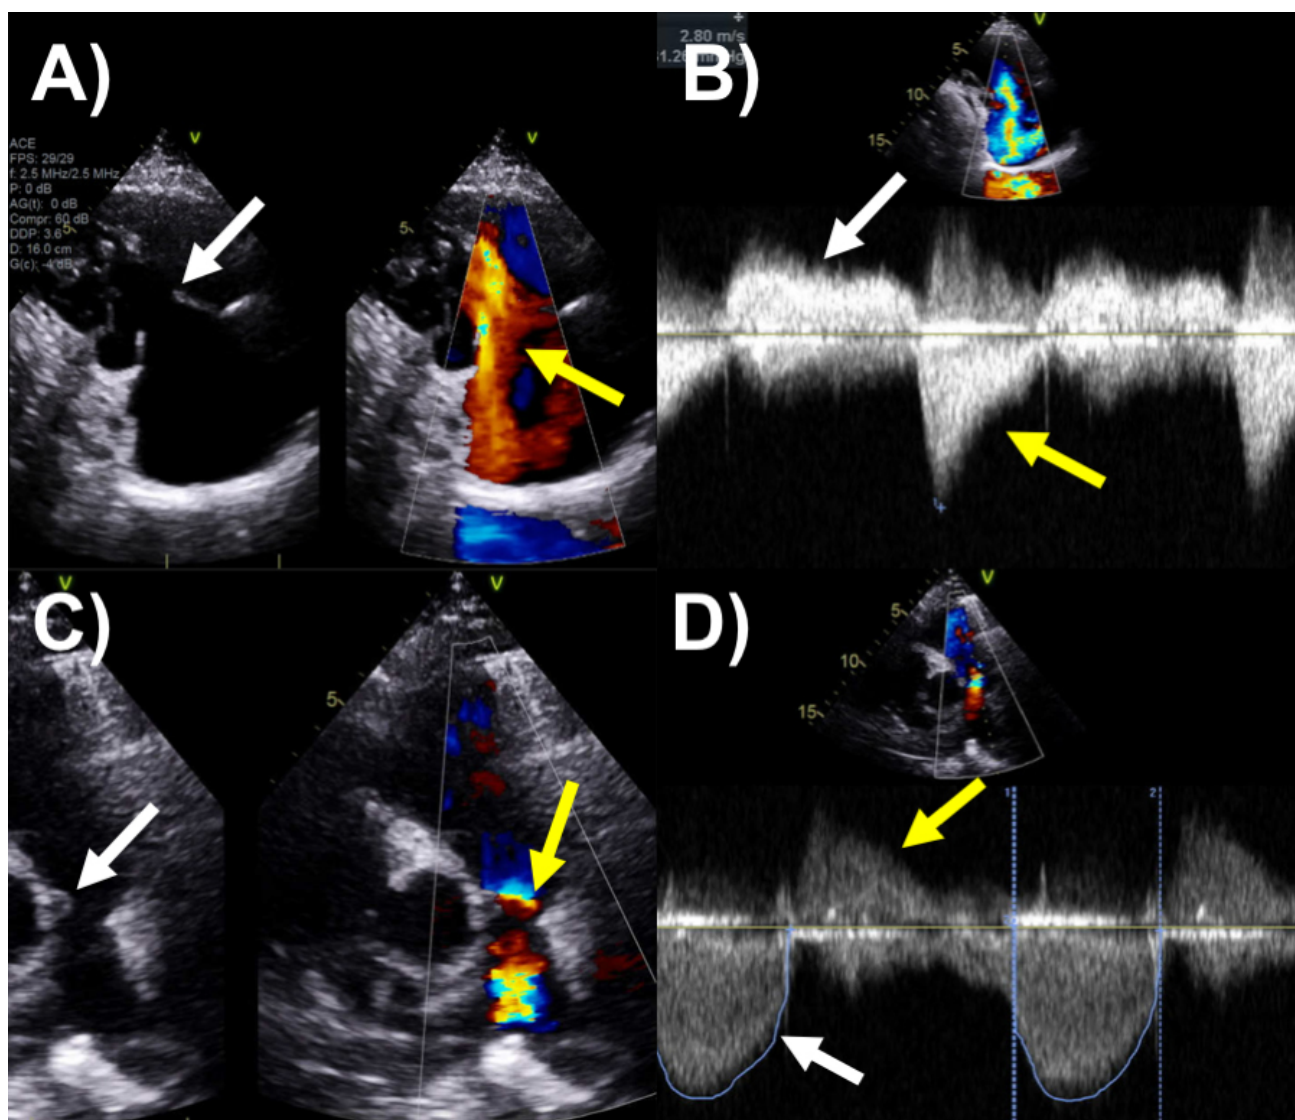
Transthoracic echocardiography case carcinoid tricuspid and pulmonary valve heart disease. (A) Parasternal tricuspid valve inflow view showing fixed thickened tricuspid valves (white arrow) with flow acceleration indicating stenosis on color-Doppler (yellow arrow). (B) Continuous wave Doppler of tricuspid valve showing severe tricuspid stenosis inflow (white arrow) and regurgitation (yellow arrow). (C) Pulmonary artery and valve view showing thickened pulmonic valve leaflets (white arrow) with flow acceleration indicating stenosis on color-Doppler (yellow arrow). (D) Continuous wave Doppler of pulmonic valve showing significant pulmonic stenosis inflow (white arrow) and regurgitation (yellow arrow).
